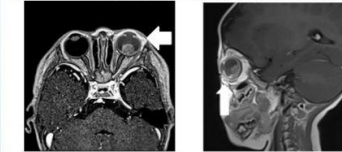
(left) Axial image of T1-weighted post-contrast MRI image. (right) Oblique sagittal T1-weighted post-contrast MRI image of the left eye of a 13-month-old boy with retinoblastoma. Increase in contrast enhancement of the anterior chamber is seen in left eye when comparing with the normal right eye (arrow).
